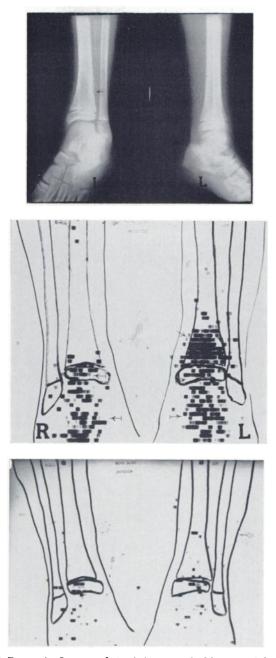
Case III. Pyogenic Osteomyelitis. (a) Internal oblique and lateral roentgenogram on January 28, 1965, was interpreted as benign cortical defect (\longrightarrow) of left tibia. (b) Anterior scan of ankles on February 1, 1965, confirmed osteomyelitis of metaphysis of left tibia (\longrightarrow) . Note symmetrical sites of normally increased ⁸⁵Sr over distal tibia and tarsal bones $(|\longrightarrow)$. (c) After antibiotic therapy, anterior scan of ankles on April 5, 1965, revealed subsidence of the osteomyelitis.
